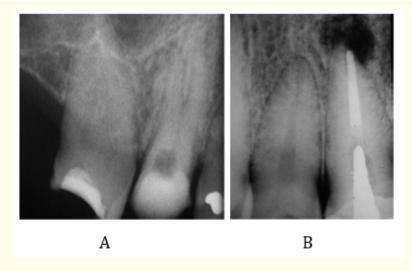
Showing A. Widening of periodontal ligament. B. Well-defined radiolucency seen at peri-apex region suggestive of acute periapical abscess [4].
